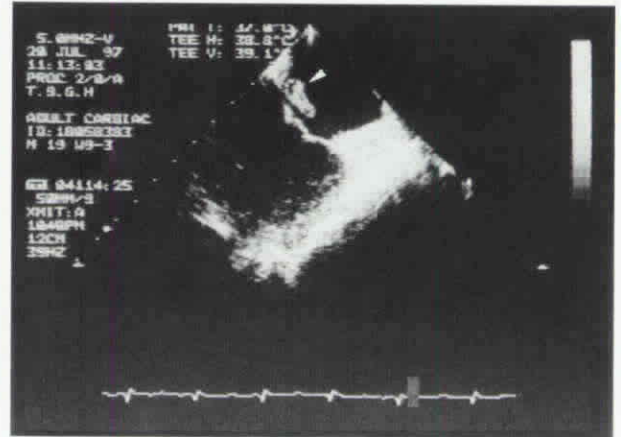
Transesophageal echocardiogram disclosed vegetations on the anterior leaflet of mitral valve (arrow).
